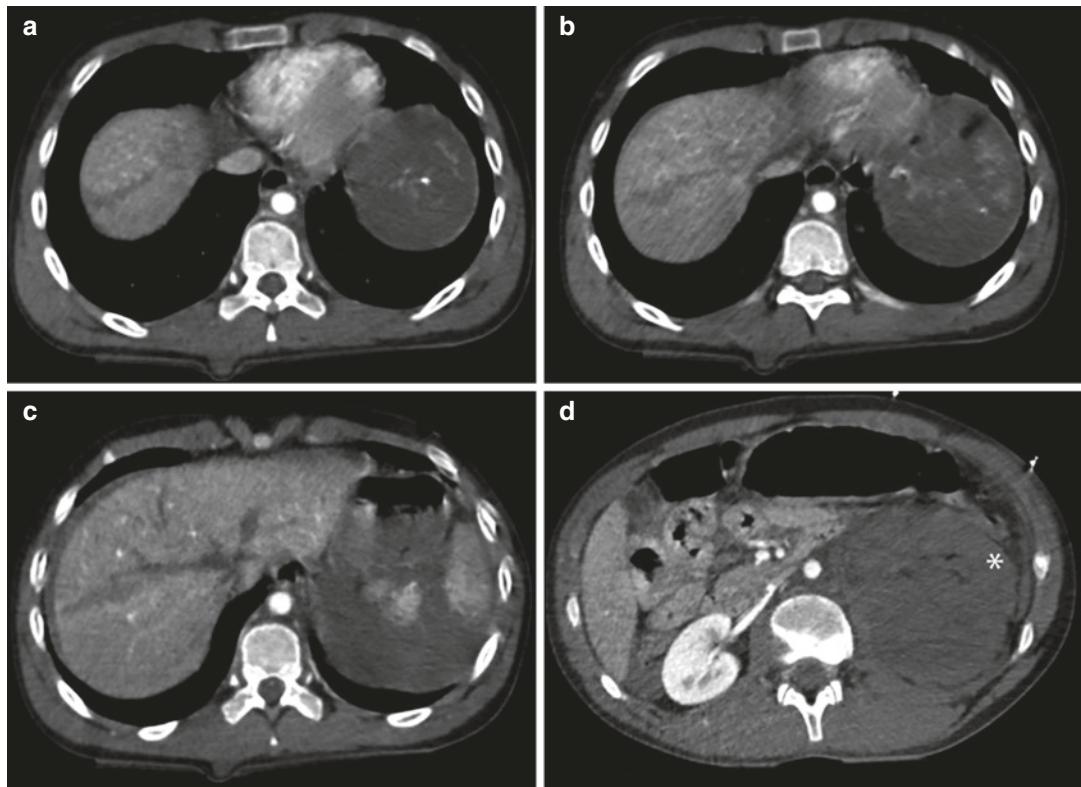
A 16-year-old male patient admitted to the emergency department after high-energy trauma, who was imaged with a “split-bolus” CT protocol to lower the radiation dose. IV contrast-enhanced CT image shows a linear hypodensity at segment VIII of the liver (a–c), which was misinterpreted as a deep laceration, a shattered spleen (c), and a left renal avulsion (d, asterisk). At surgery, no liver injuries were identified. A follow-up CT in the portal
